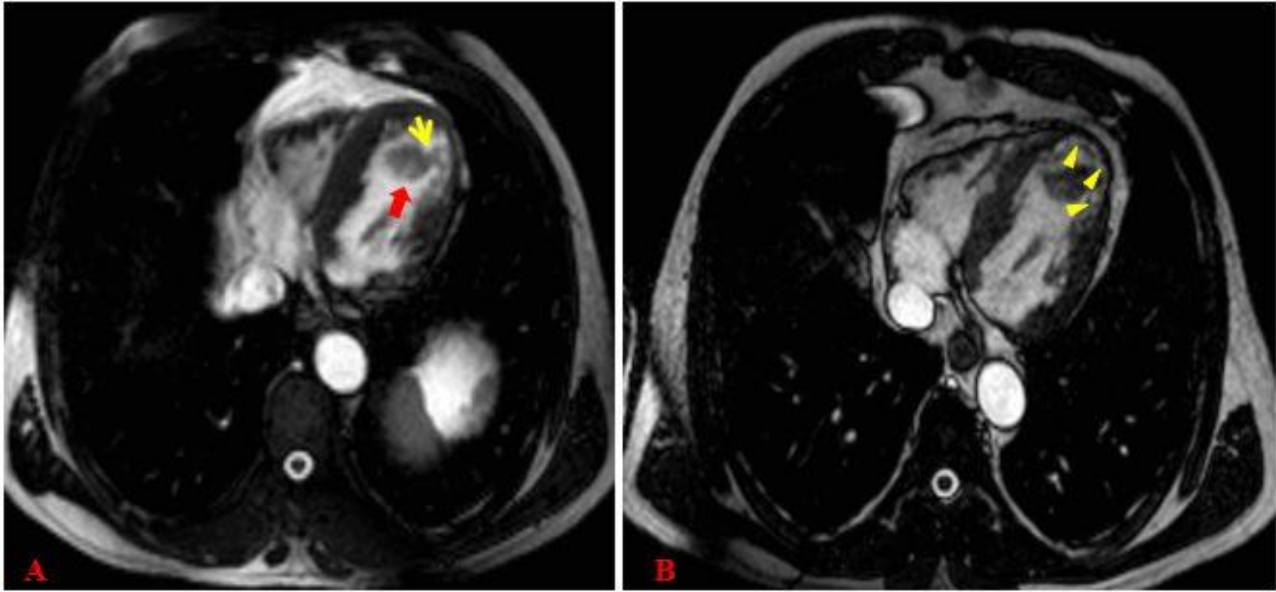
MRI shows a thrombus (red arrow) attached to apiko-lateral segment with pedunculus (yellow arrow)(A). Delayed contrast enhancement image, obtained in horizontal long-axis view (B) shows a hyperenhancing area involving apex and apiko-lateral segments of the left ventricle.
